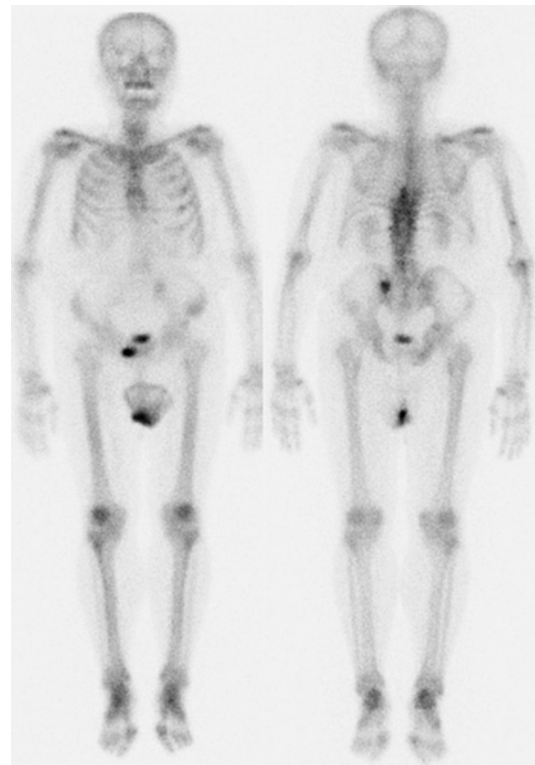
^{99m}Tc bone scintigraphy at the time of bone marrow metastasis diagnosis. Whole-body ^{99m}Tc bone scintigraphy showed almost no abnormal uptake in the whole body excluding small uptake in the sacrum, reflecting a sacral insufficiency fracture.
